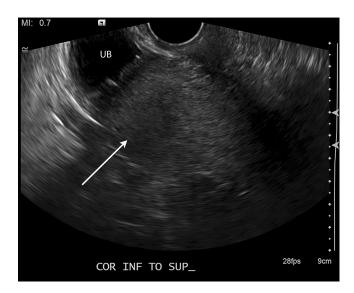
Coronal grayscale transvaginal ultrasound image of the pelvis. Note that the uterus is not demonstrated in its usual anatomic orientation (*arrow*). *UB* urinary bladder.
